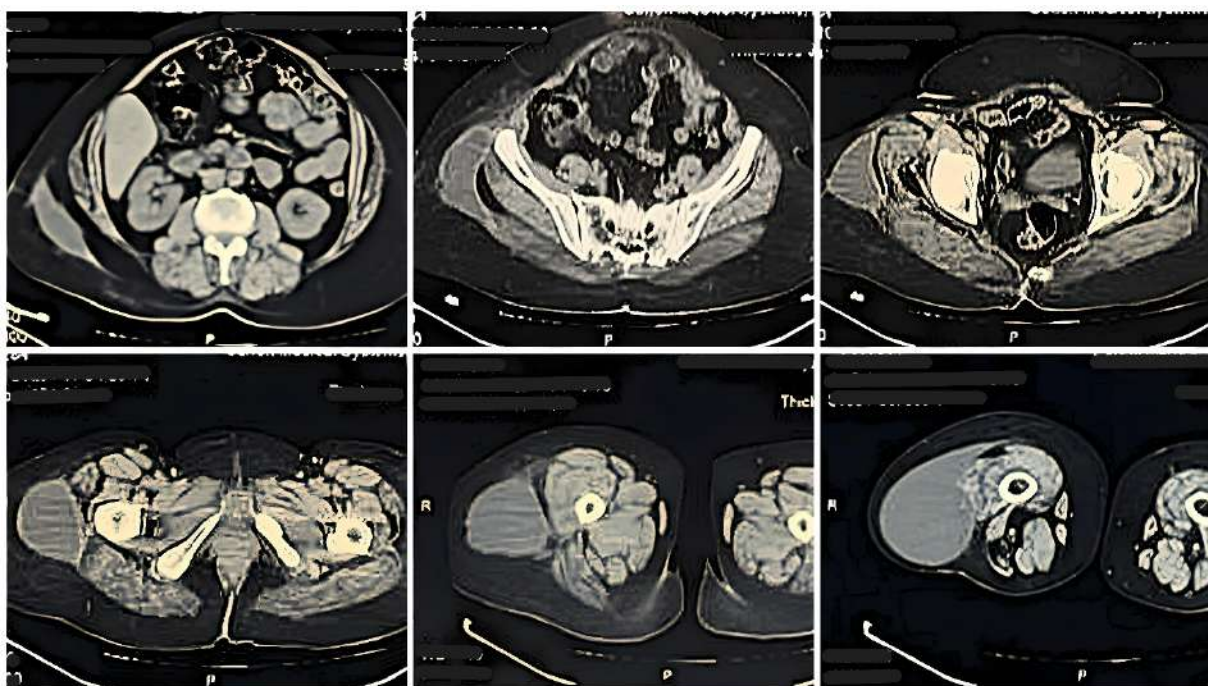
Axial cuts of CT scan demonstrating the extent of the MLL – starting cephalad to the right iliac crest, extending caudally till the right knee joint
